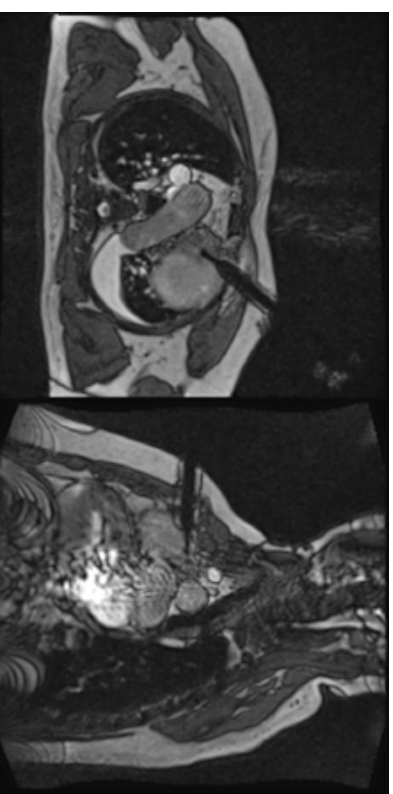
biopsy of a mediastinal mass using an anterior approach. The good contrast resolution of MRI allows to avoid targeting the necrotic parts of the tumor.
